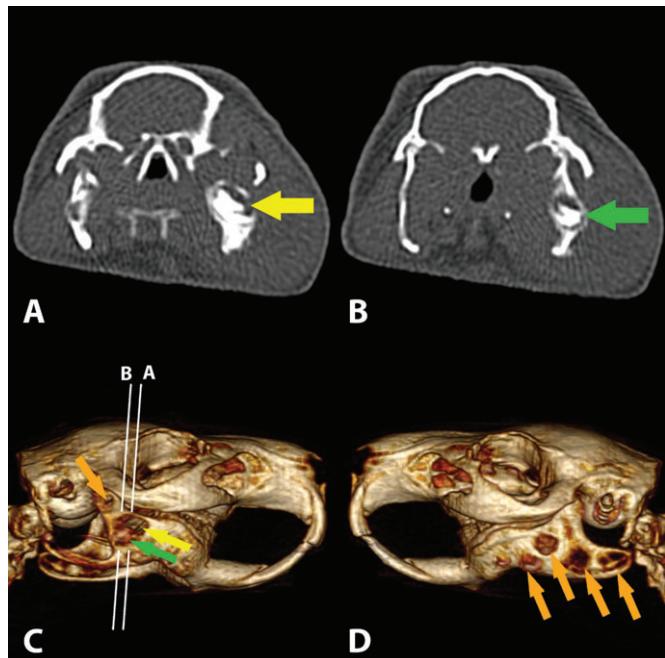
Computed tomography of the skull. (A, B) Axial views. Note the curved and deformed reserve crown (A, yellow arrow) and diseased apex (B, green arrow) of the right fourth cheek tooth, surrounded by an area of bone lysis. The temporomandibular joints are not affected (B). Scanning planes correspond to white lines shown in (C). (C, D) Three-dimensional (3D) volume reconstruction of the skull. Reserve crown (yellow arrow) and apex (green arrow) of the affected cheek tooth are visible, as well as the fenestration of the body of the mandible. Lysis of most of the right angular process of the mandible is present, as well as a point of lysis at the condylar process (orange arrow). Areas of bone lysis were also present at the left mandible (orange arrows) (D)
